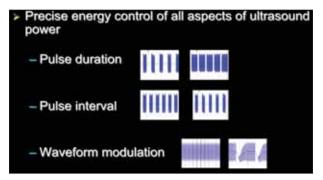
The Attune energy management system allows the surgeon to customize all aspects of the ultrasound pulse to their technique and allows customized pulse duration and interval, while the Advanced Waveform Modulation allows variable wavefront duration and depth.
